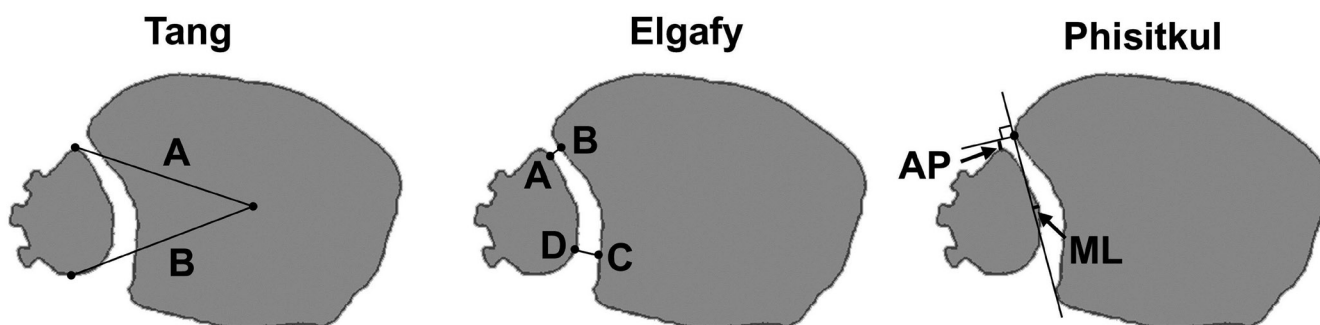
Clinical measurements made manually on CT scans and calculated automatically by the computer algorithm. Measurements are shown on 2D cross-sections through the segmented 3D volume and the irregularities in the fibular contour are screw heads used to ensure consistent clamp placement for scanning. The Tang measurement is expressed as A/P, and indicates a measure of fibular rotation. The Elgafy measurements and the Phisitkul measurements indicate fibular translation.
